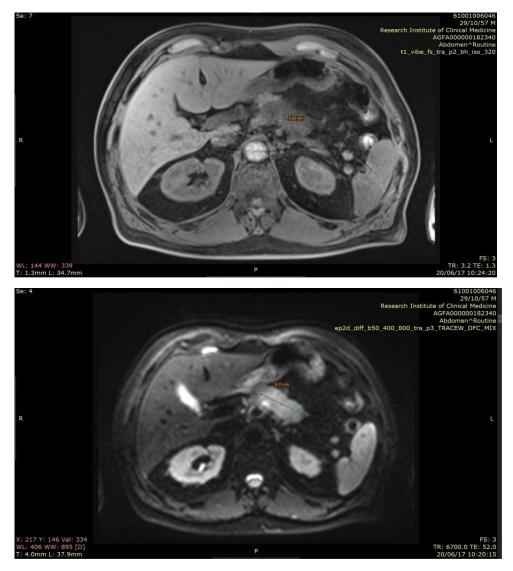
Patient Z.V, 60 years old. Magnetic resonance imaging of the abdominal organs before surgery. Preliminary diagnosis: pancreatic cancer.
